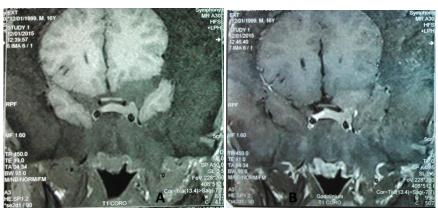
Cerebral MRI showing pituitary adenoma in the left (A: T1 coronal sequence without contrast. B: T1 coronal sequence with contrast)
